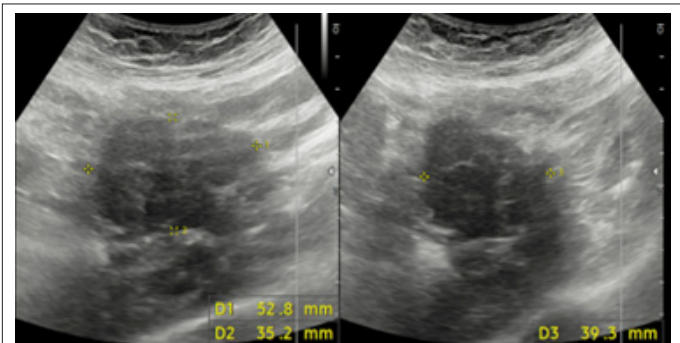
Ultrasound images of left lower quadrant mass lesion, with axial (left) and longitudinal (right) original measurements.
